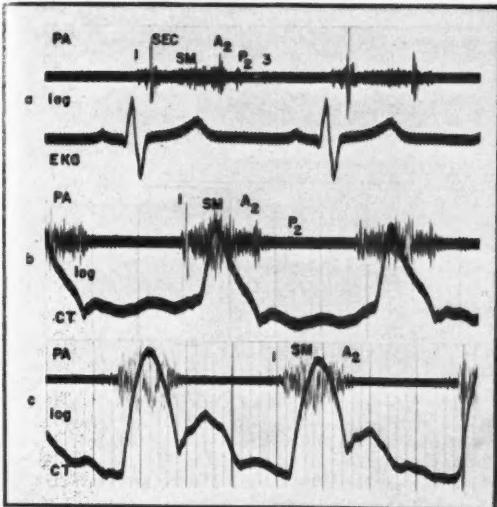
Second sound in isolated pulmonary valvular stenosis. (a) Mild pulmonary stenosis. Pressure gradient RV-MPA—40 mm. Hg. A₂-P₂ interval 0.07 second and diminished P₂. Third sound. Systolic ejection click following the first sound by 0.07 second. Pulmonary systolic ejection murmur with mid-systolic accentuation. (b) Moderate pulmonary stenosis. Pressure gradient RV-MPA—100 mm. of mercury. A₂-P₂ interval 0.14 second. P₂ decidedly diminished. A₂ precedes the dicrotic notch in the CT by 0.02 second and P₂ follows it by 0.12 second. Pulmonary systolic ejection murmur with mid-systolic accentuation going through A₂. (c) Severe pulmonary stenosis. Pressure gradient RV-MPA—130 mm. of mercury. P₂ is absent. A₂ cannot be well identified because the murmur goes through. Pulmonic systolic ejection murmur with mid-systolic accentuation.
